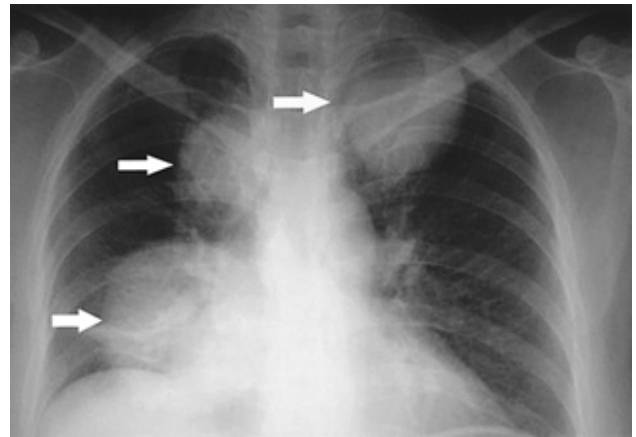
Follow-up chest X-ray shows markedly increased metastatic nodules of right lower lobe and left upper lobe and newly developed metastatic nodule in right upper lobe.
